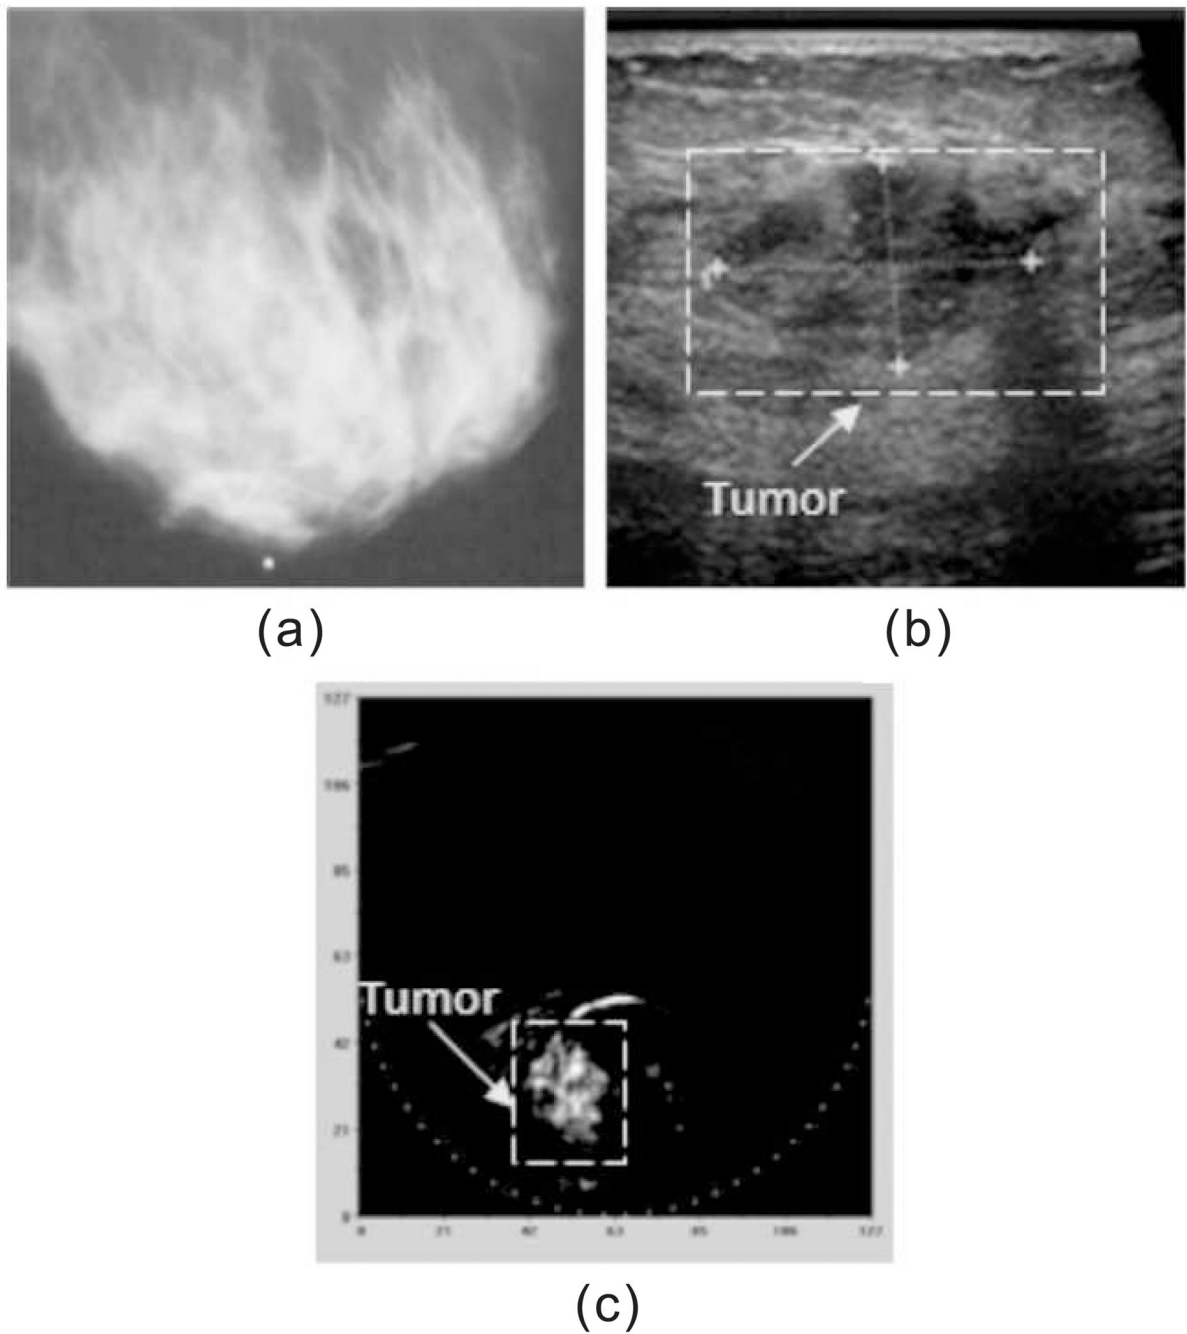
Example of the clinical images showing the breast cancer: (a) mediolateral mammography, (b) ultrasonic, and (c) mediolateral optoacoustic images. High contrast of the object in the OA image implies the advanced angiogenesis indicative of a malignant tumor. Reprinted with permission from [47]
